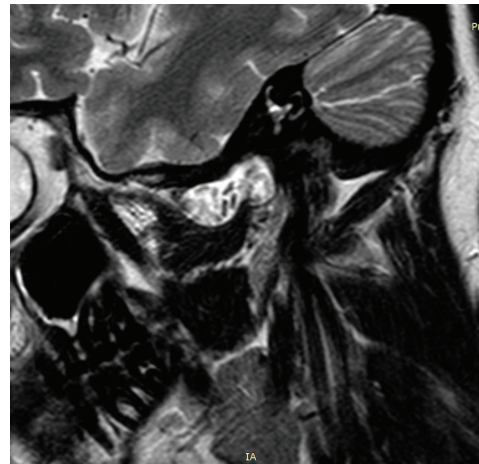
MRI - saggital scan through left TMJ, cartilaginous bodies visible in the articular cavity
